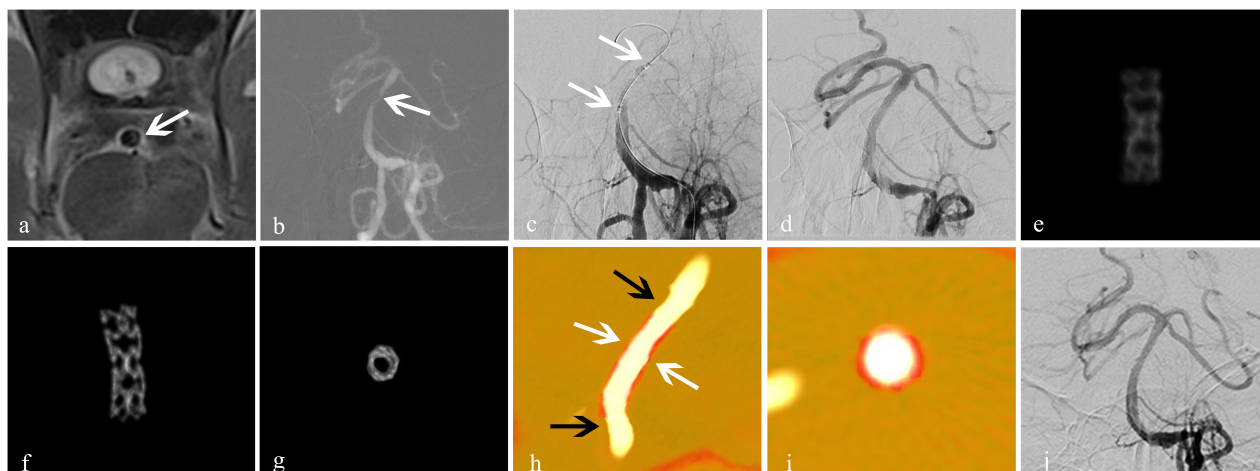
Treatment for an atherosclerotic stenosis in the basilar artery with the Apollo™ stent. A 56-year-old man presented with dizziness of 2-week duration. (a) High-resolution MRI showed stenosis of the basal-artery trunk (white arrow); (b) 2D-DSA showed severe stenosis (80%) of the basilar-artery trunk (white arrow); (c) an Apollo balloon-expandable stent measuring 2.5 mm × 8 mm was placed (white arrow); (d) DSA showed improved blood flow with good expansion of the stent, and residual stenosis was 5%; (e) conventional FDCT showed the blurred metal struts of the stent with an image-quality score of 0; (f,g) HR-FDCT showed that the stent struts were clear and expanded completely, and image quality was improved significantly with a score of 2; (h,i) Dual volume three-dimensional fusion images showed good apposition of the stent to the vessel wall (stent, white arrow; vessel wall, black arrow); (j) follow-up DSA at 6 months showed durable stent patency. Panels (e-g) were obtained *in vivo*.
